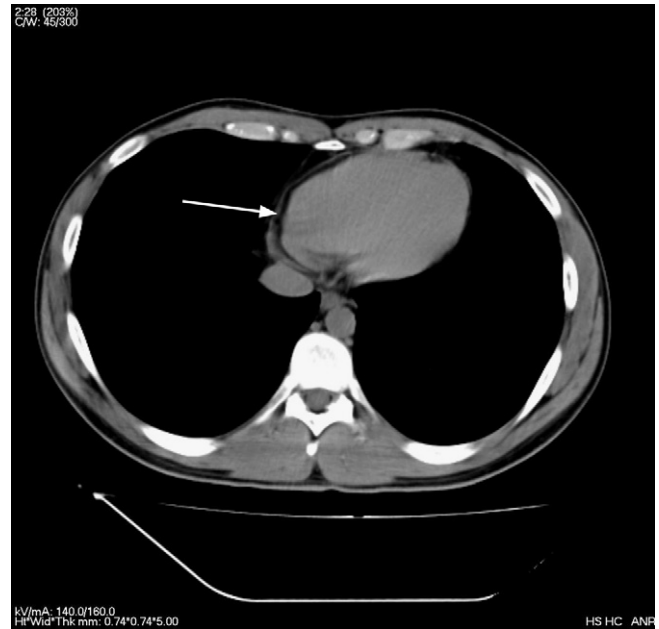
Chest CT scan revealing air in the mediastinum (arrow).
